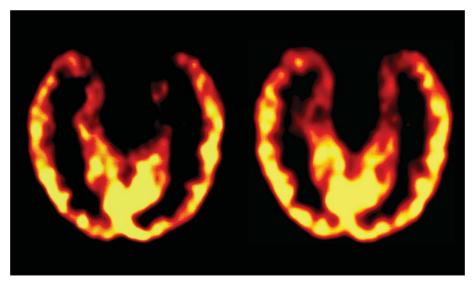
[11C] flumazenil-PET (FMZ-PET) was repeated twice at one week interval in the same TLE patient whose MRI was normal. The first FMZ-PET showed a clearcut left mesial temporal decreased FMZ binding, which has vanished at the second investigation.
